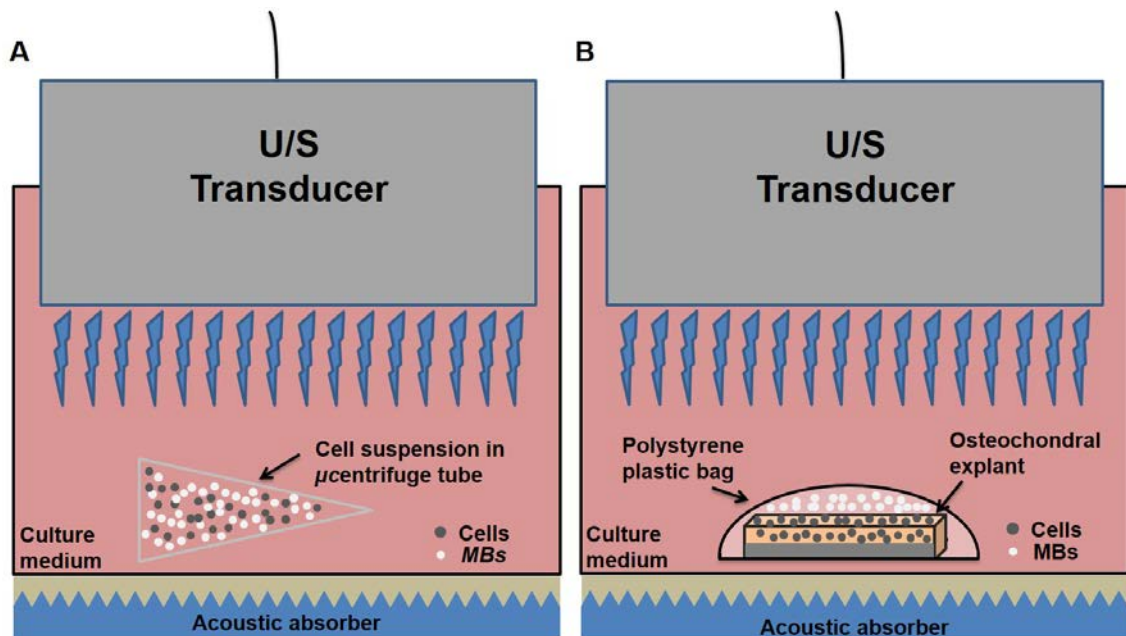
Configuration of ultrasound exposure for *in vitro* cytotoxicity test of UMMD. Versatile function generator is used to produce various duty cycle adjusted waveforms either continuous or pulsed waves. Radio frequency power amplifier amplifies waves from function generator and ultrasonic transducer converts the electric pulses to mechanical ultrasounds.
